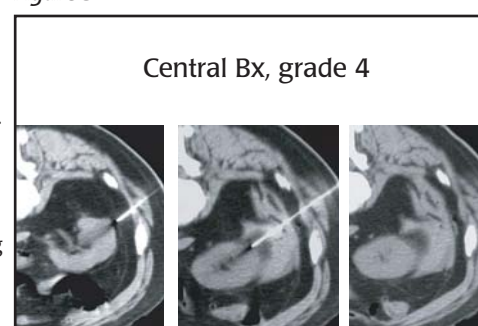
CT images at placement, just after biopsy, and 5 minutes later show grade 4 bleeding from a central placement in the lower pole of the left kidney. An 18 g needle was used for three cores. Bleeding persisted and eventually led to angiographic embolization of the bleeding arterial branch. However, the patient eventually died during this hospitalization from related problems.
